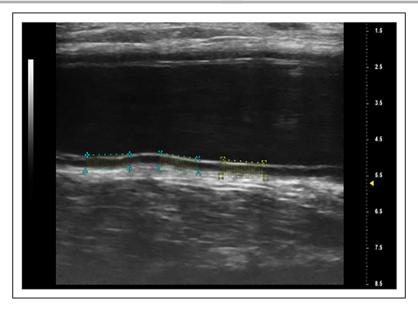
Two-dimensional ultra-high-resolution ultrasound of radial arterial intimal-medial thickness (IMT) using a 55-MHz probe.
